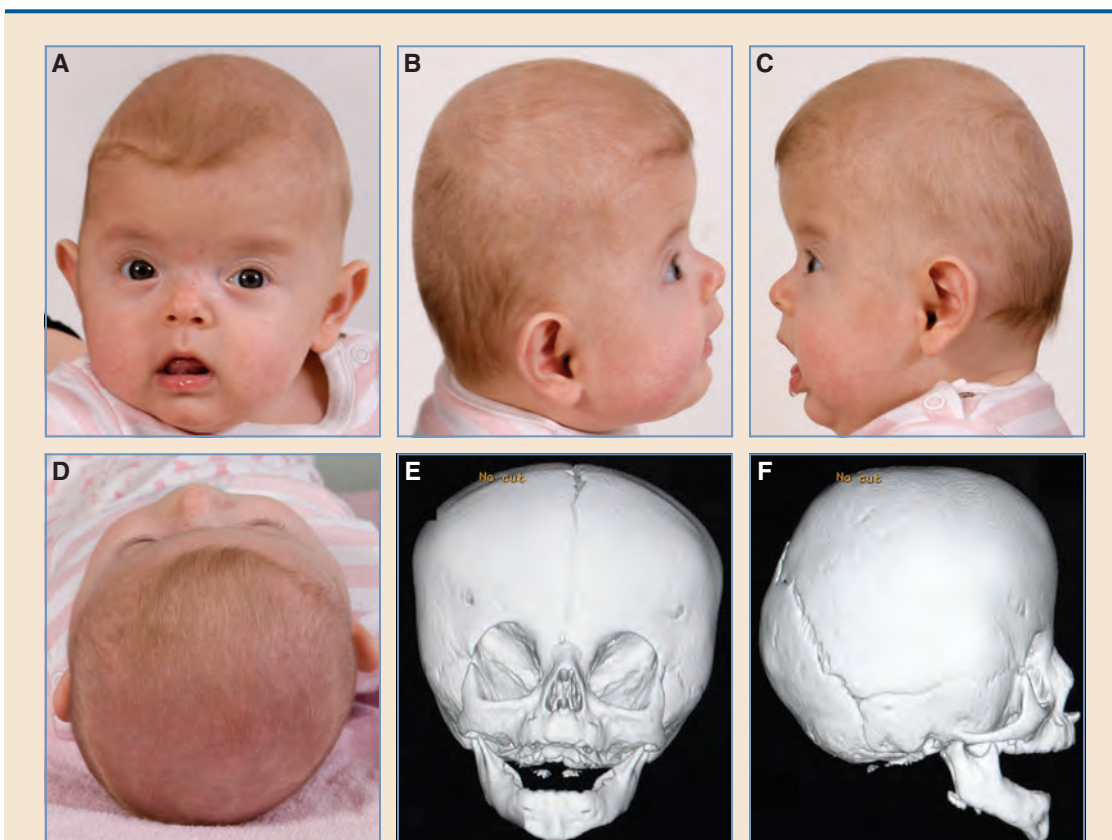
A-D, Although bilateral coronal synostosis is usually associated with a syndrome, it can rarely occur as an isolated finding and may be distinguished from syndromic craniosynostosis by the absence of midface retrusion. Fusion of both coronal sutures in this 5-month-old girl resulted in a tall, foreshortened skull with bitemporal bulging and recession of the supraorbital rims (turribrachycephaly). E and F, CT imaging shows no evidence of midface retrusion in this nonsyndromic patient.
